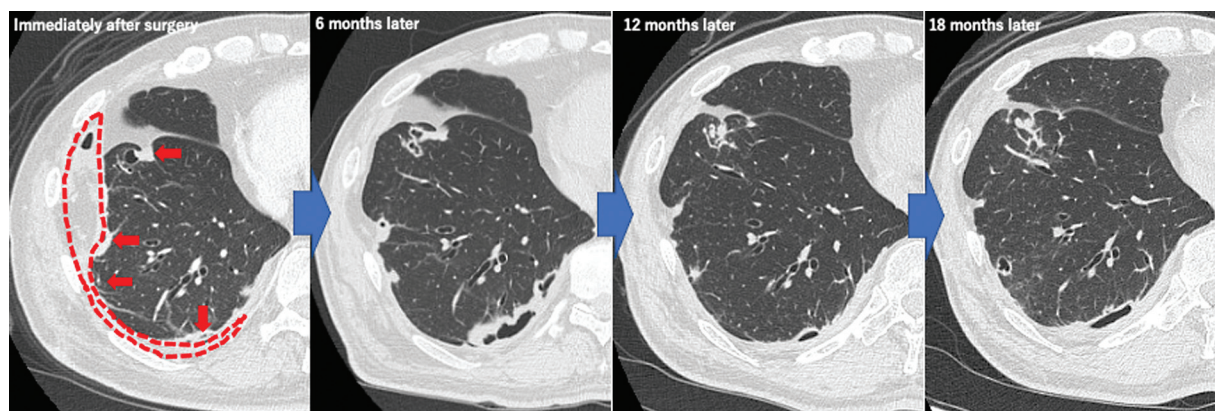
Computed tomography scan of the patient after the omentum filling. Some rheumatoid nodules are enlarged, while others are small. Despite repeated increase and decrease in the nodules, no recurrence of pneumothorax is observed, probably because the nodules adhered firmly (dotted line: pedicled omentum-filling area; red arrows: rheumatoid nodules over time).
